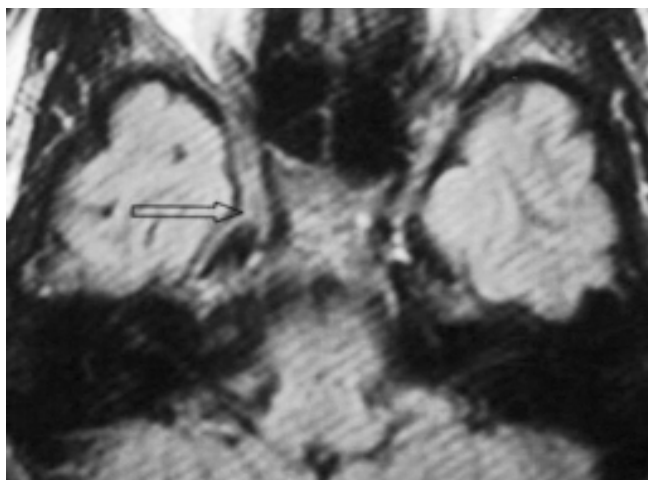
Axial T2 WI FLAIR Expansion of the right cavernous sinus
